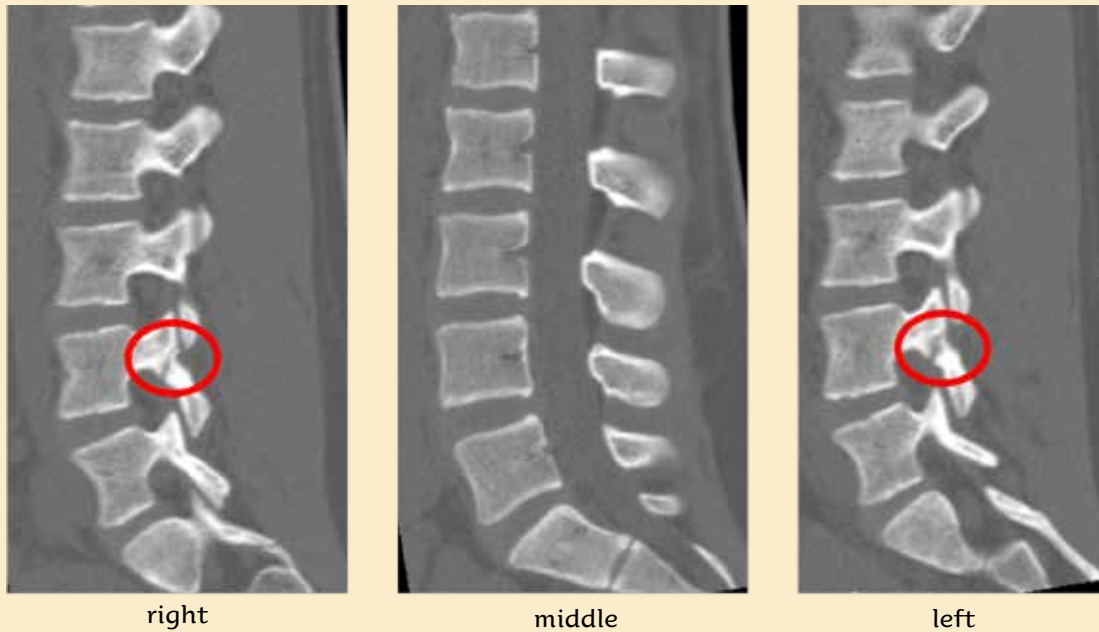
CT scan where the red circle indicates the stress fracture in the pars interarticularis, just present on both sides of the back.
